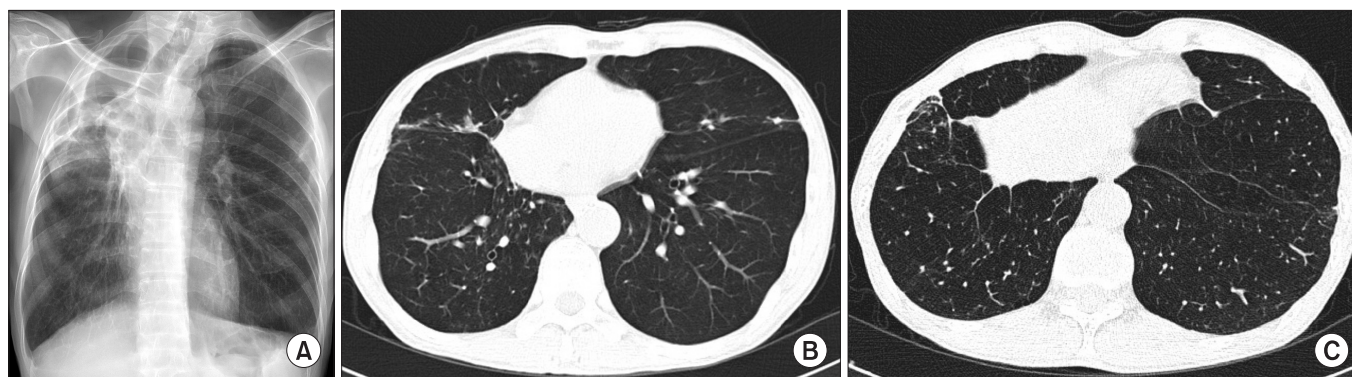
Chest X-ray (A) and low-dose chest computed tomography (B, C) images taken 12 months after the start of treatment showing reduced number and extent of nodules.
